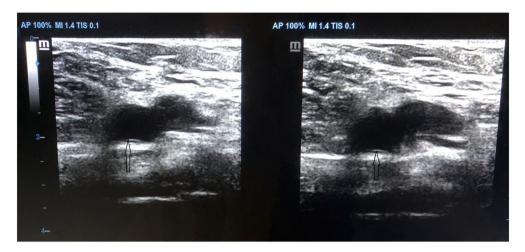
Two point compression ultrasonography showing non-compressible left popliteal vein.
